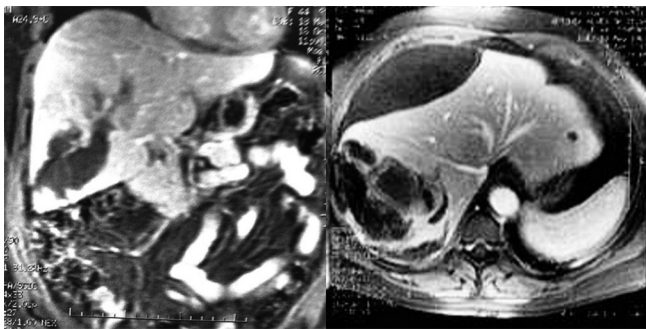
MRI showing adenoma and bulky subcapsular hematoma
